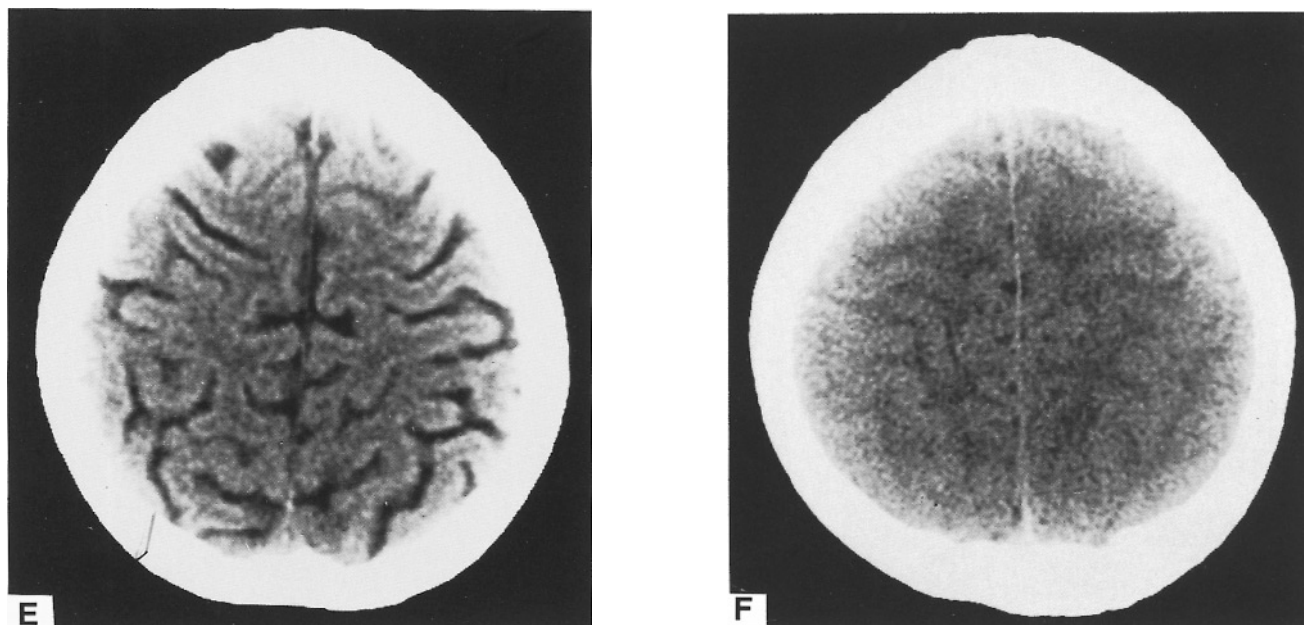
CT sections through the basal cistern (A,B), third ventricle (C,D), and cortical sulci (E,F) of a 7-year-old boy with Wilm's tumor 1 year after therapy completion (A,C,D), and of a boy of the same age with normal CSF spaces (B,D,F).
